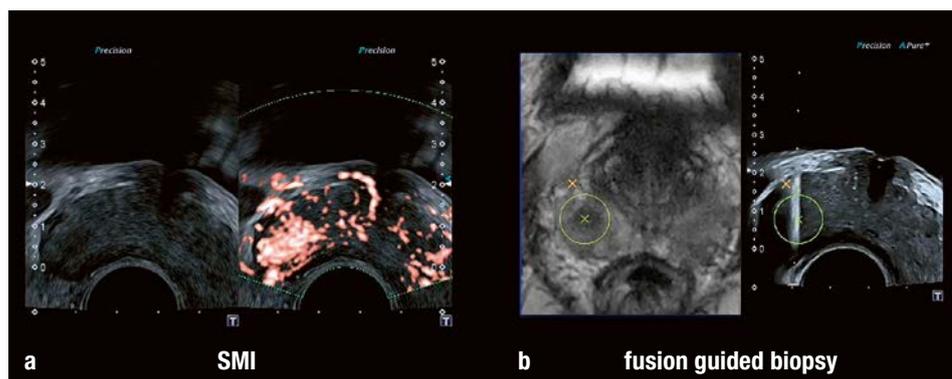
(a–b): cSMI with contrast enhancement in dual-screen mode simultaneously with the corresponding B-mode image (a) and the MRI/US-fusion guided biopsy (b) of the lesion identified in (a).
